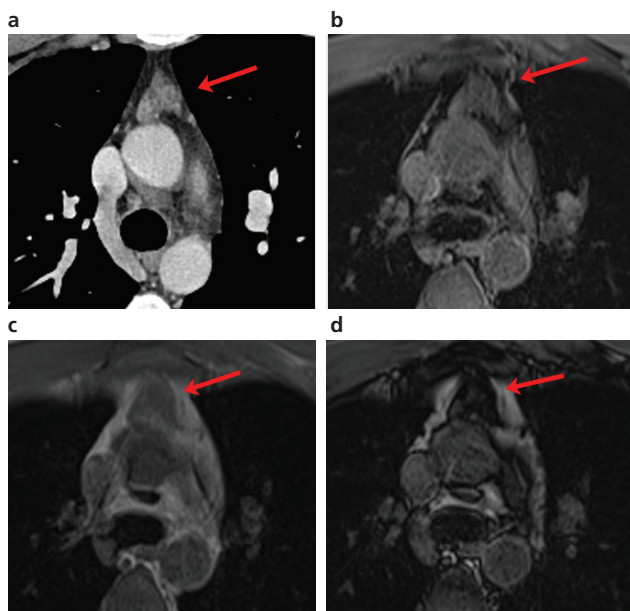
Thymic hyperplasia. Axial non-contrast-enhanced CT scan (A) shows a prevascular mediastinal mass with soft-tissue density and nodular morphology, with a slight enhancement after paramagnetic contrast administration on MRI (B). The lesion shows a loss of signal intensity on out-of-phase gradient-echo sequences (C and D).
